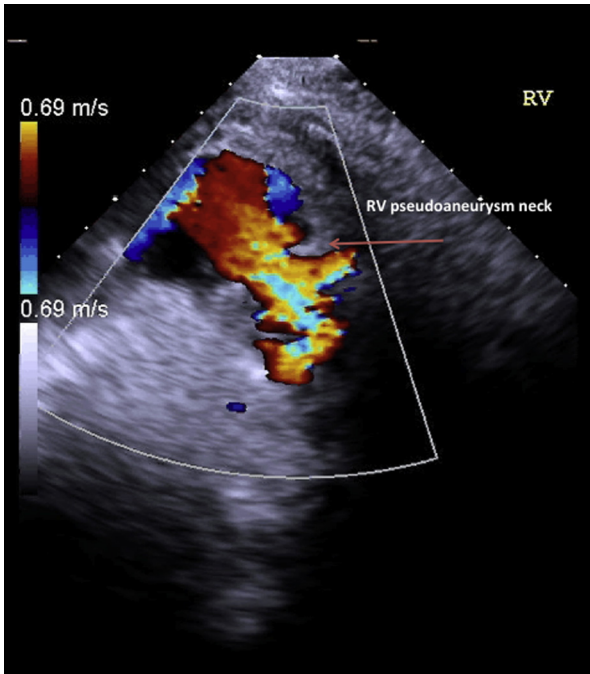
Transthoracic echocardiography with color Doppler; arrows point to the pseudoaneurysm neck.
